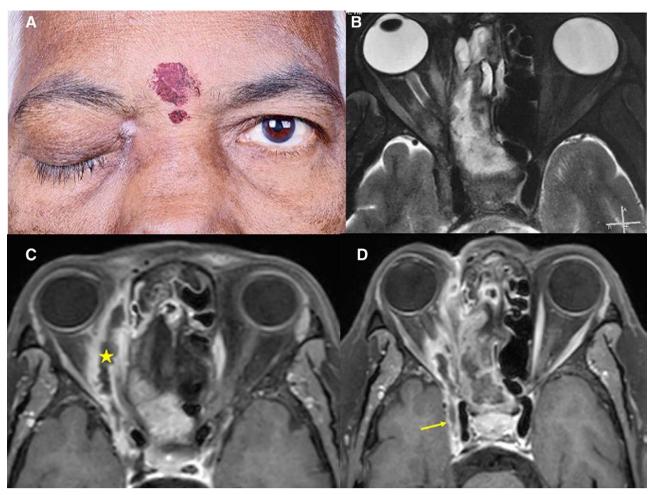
Clinical picture and orbital MRI with contrast of a patient with right rhino-orbital-cerebral mucormycosis. A, Standard photograph with right complete ptosis and a superior discharging sinus. B, T2 weighted MRI in axial cut demonstrating the involvement of the ethmoid sinuses, orbital apex, and the cavernous sinus. C, Contrast-enhanced MRI demonstrating superior ophthalmic vein thrombosis (yellow star). D, Contrast-enhanced MRI demonstrating cavernous sinus thrombosis (yellow arrow).
